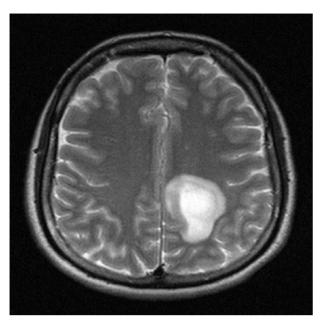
MRI of the brain showing a large left frontoparietal mass surrounding edema.
